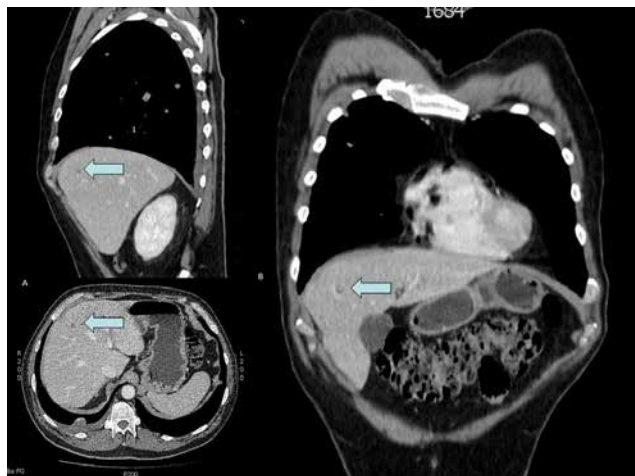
AXIAL (A) and CORONAL (B) RECONSTRUCTION on CT SCAN showing multiples hypodense liver lesions. The arrow point the biggest one of almost 10 mm of diameter.
